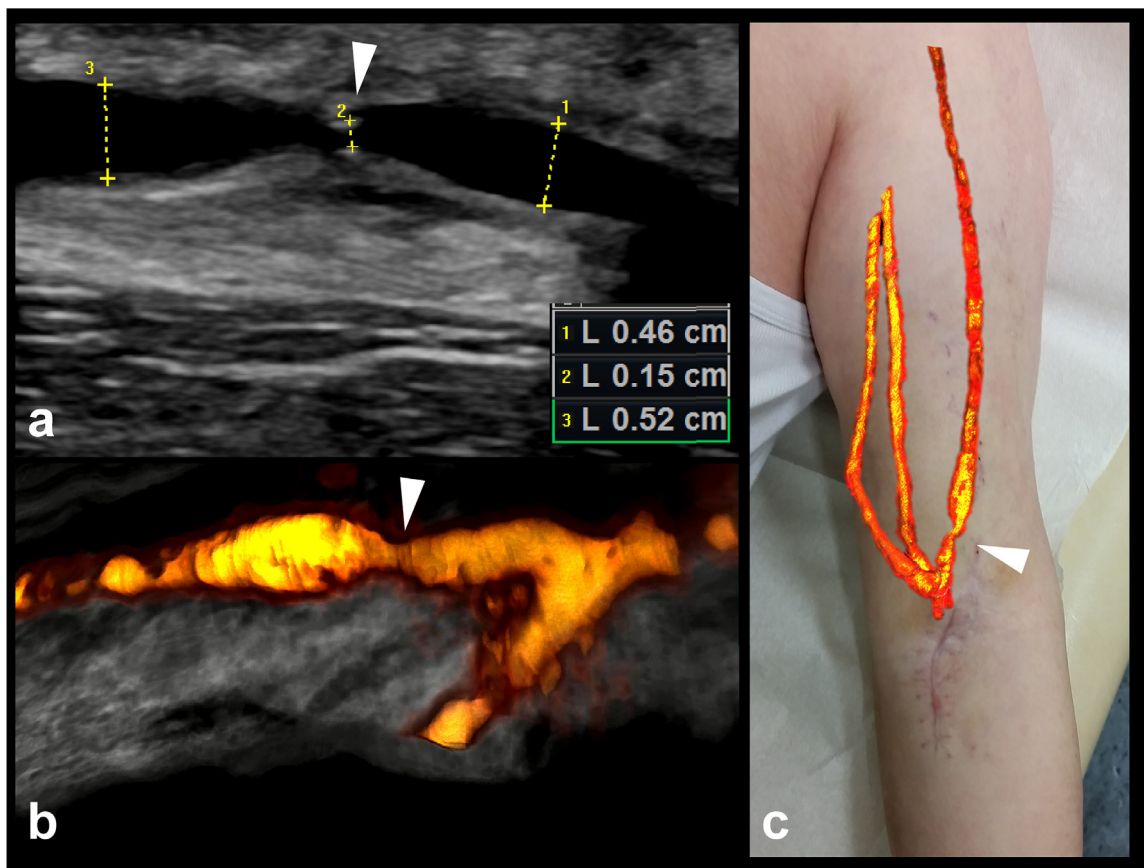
Visualizing a high-grade stenosis in an arteriovenous fistula with 3-D tomographic ultrasound. (a) B-mode shows a high-grade stenosis of the vein of the arteriovenous fistula, with decreasing blood flow within the last 6 mo to 400 mL/min and evidence of dysfunction. (b) Visualization of the stenosis by 3-D ultrasound based on power Doppler. (c) The merged image of the 3-D ultrasound image and the participant's photography serves as a map for cannulation.
